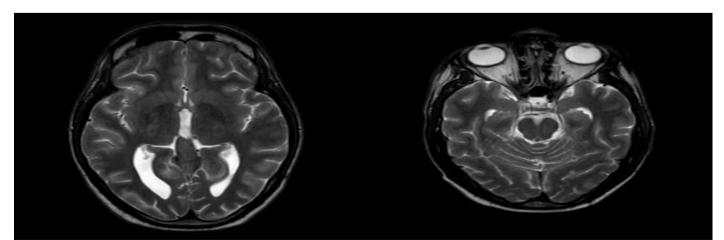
Axial views of Cerebral Post-Radiotherapy MRI Showing no Residual Tumor, Indicating a Complete Response to Treatment.
